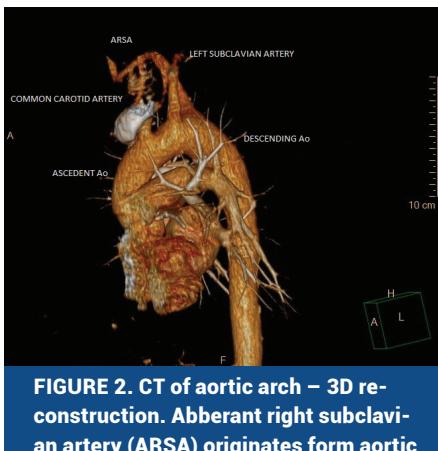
CT of aortic arch – 3D reconstruction. Abberant right subclavian artery (ARSA) originates form aortic arch as most distal branch.
